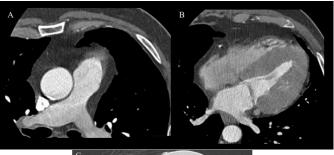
Contrast-enhanced axial CT images at the level of the main pulmonary artery (a), showing the 4 cardiac chambers (b) and in lung window (c).
